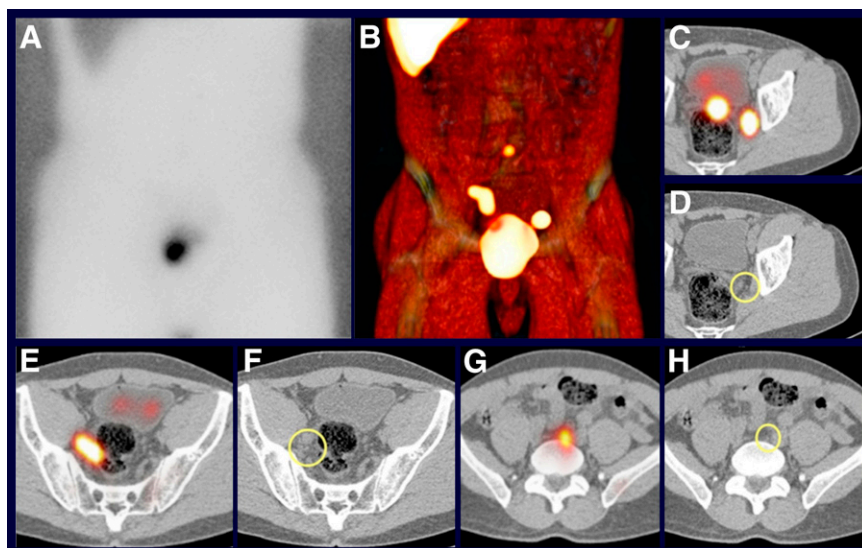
Planar imaging versus SPECT/CT sentinel lymph node imaging in a patient with prostate cancer with no evident lymphatic drainage on anterior planar imaging (A) SPECT/CT displayed with volume rendering (B) shows drainage to obturator lymph nodes in both sides of the pelvis and to a subaortic lymph node. These sentinel nodes, seen as hot spots on transverse SPECT/CT fusion images (C, E, and G), correspond with normal-sized lymph nodes (circles) on CT (D, F, H). Note that the right obturator hot spot is elongated and corresponds with a cluster of lymph nodes.
